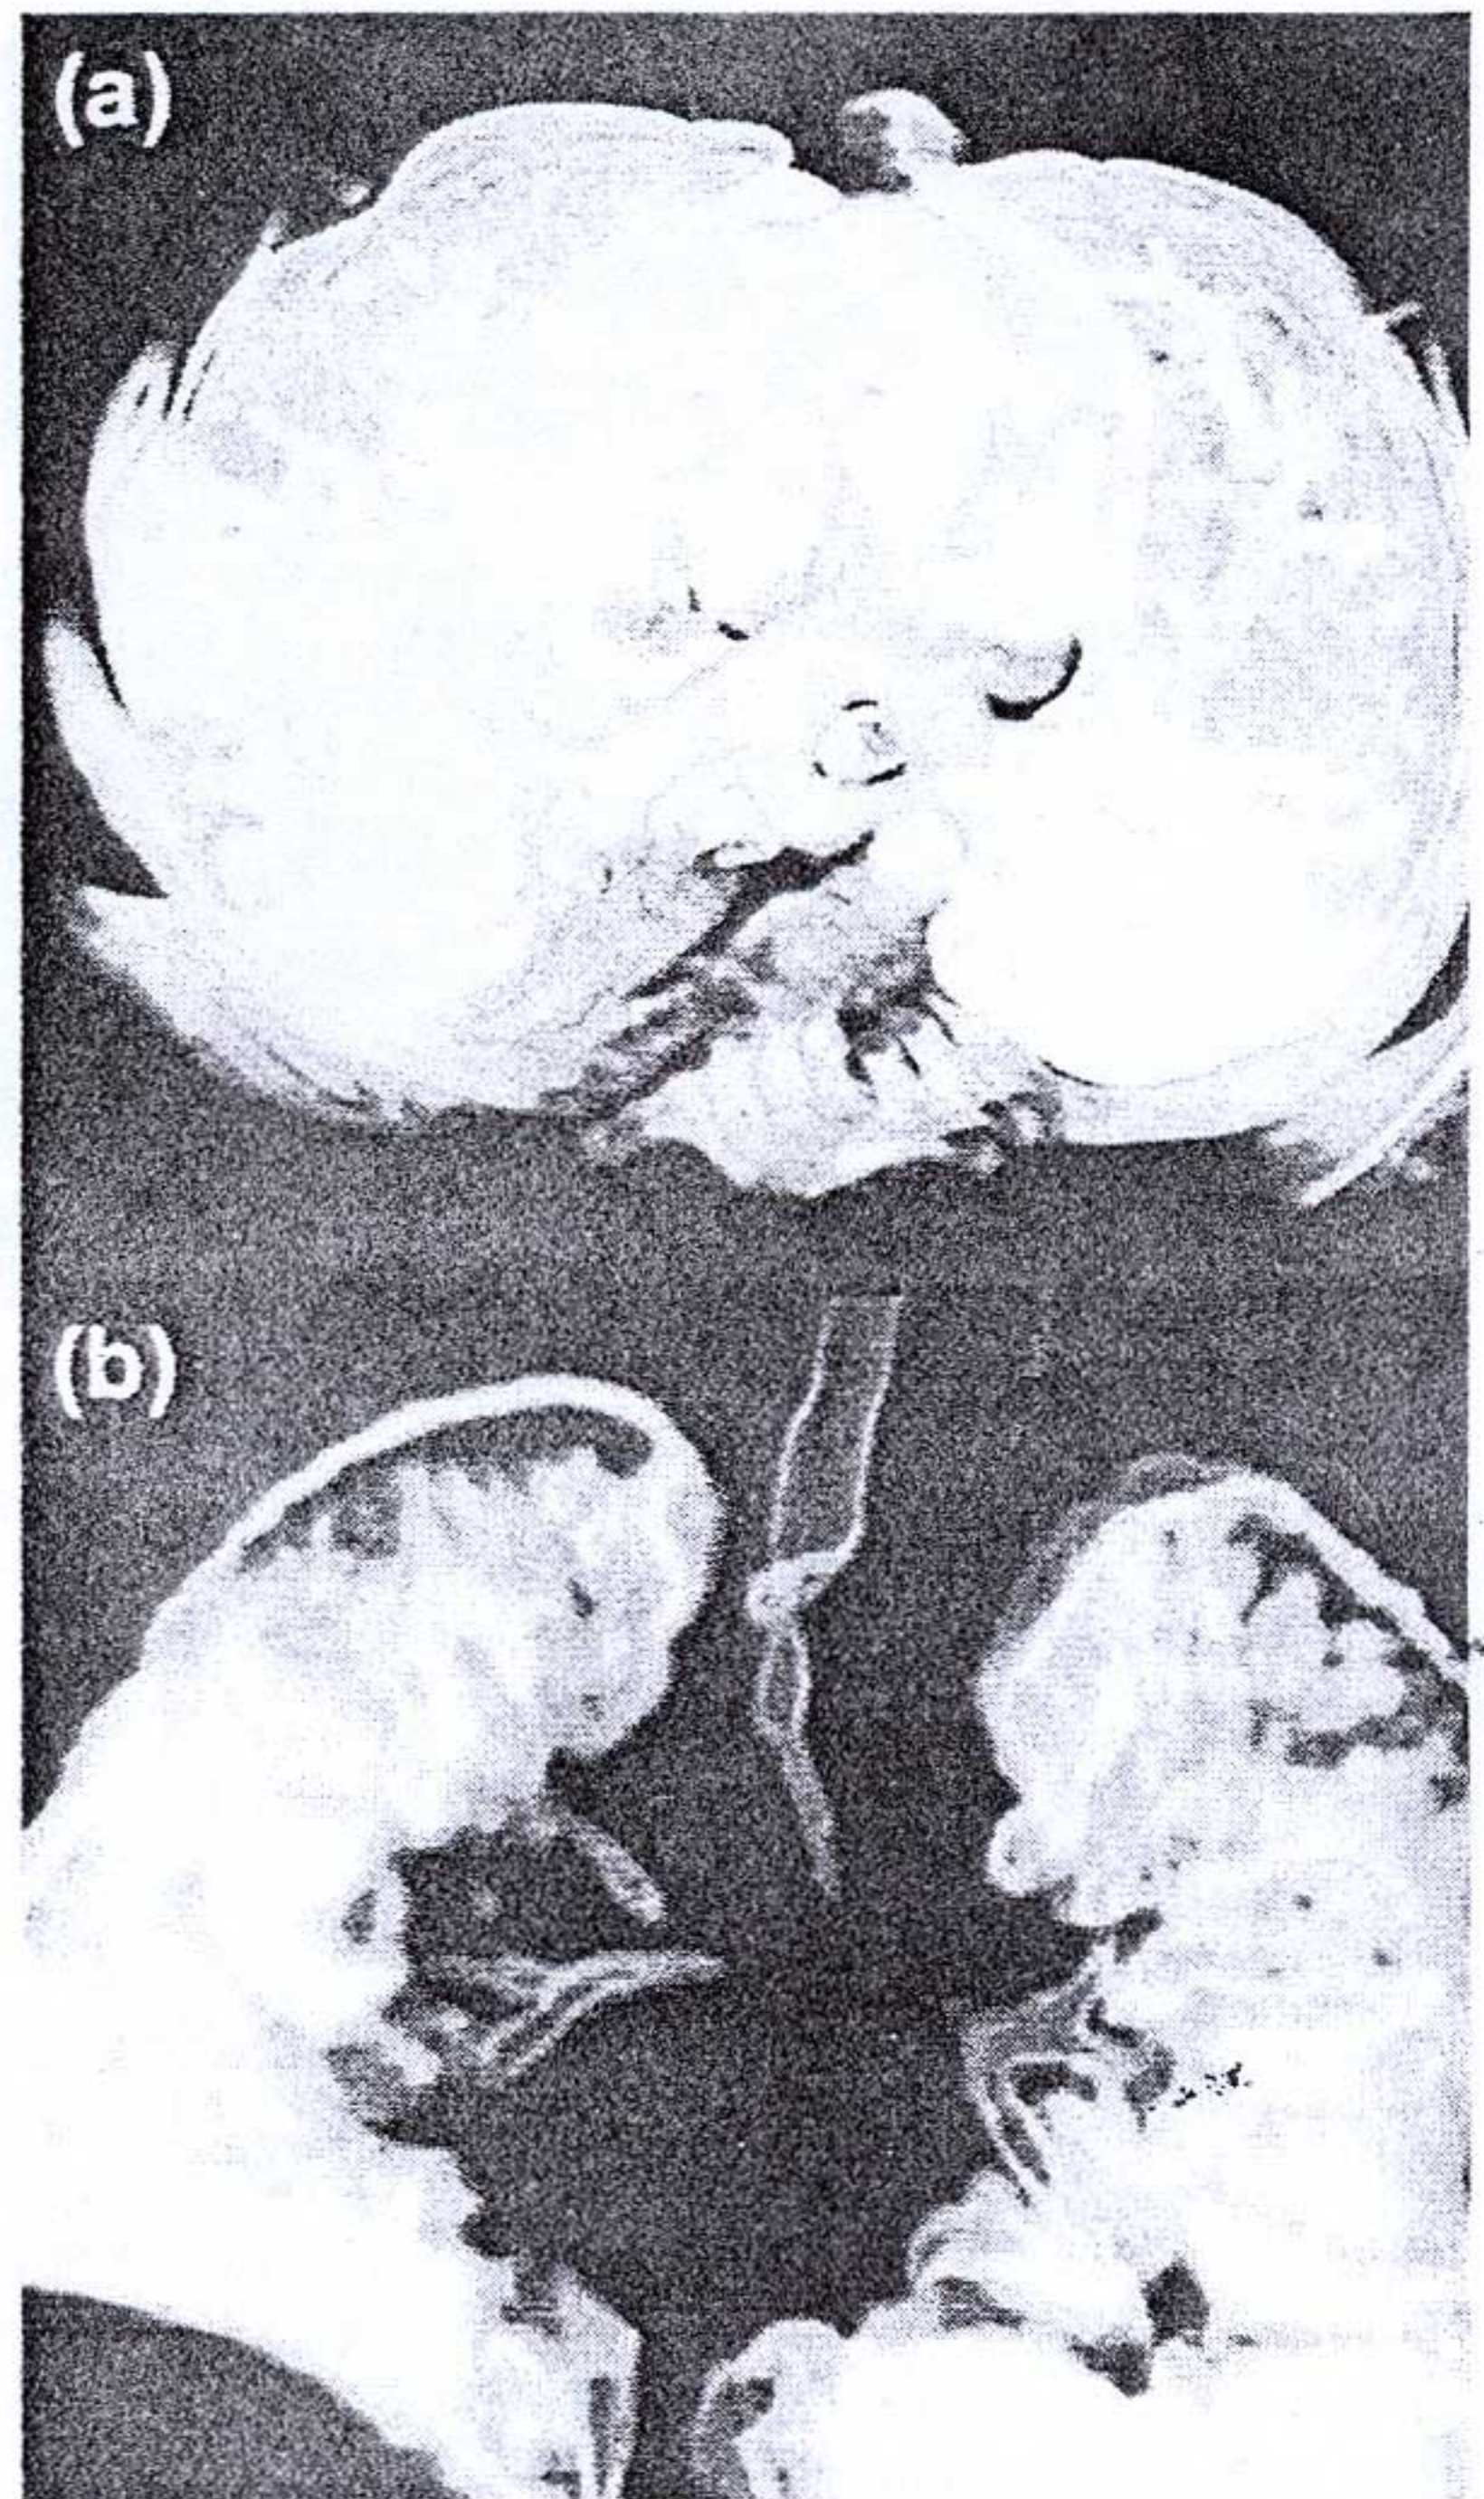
Preoperative 3D computed tomography of a 6-month-old baby whose trachea showed long-segment stenosis as well as narrowing of both main bronchi. The left pulmonary artery arises from right pulmonary artery and passes behind the trachea to the left lung.
